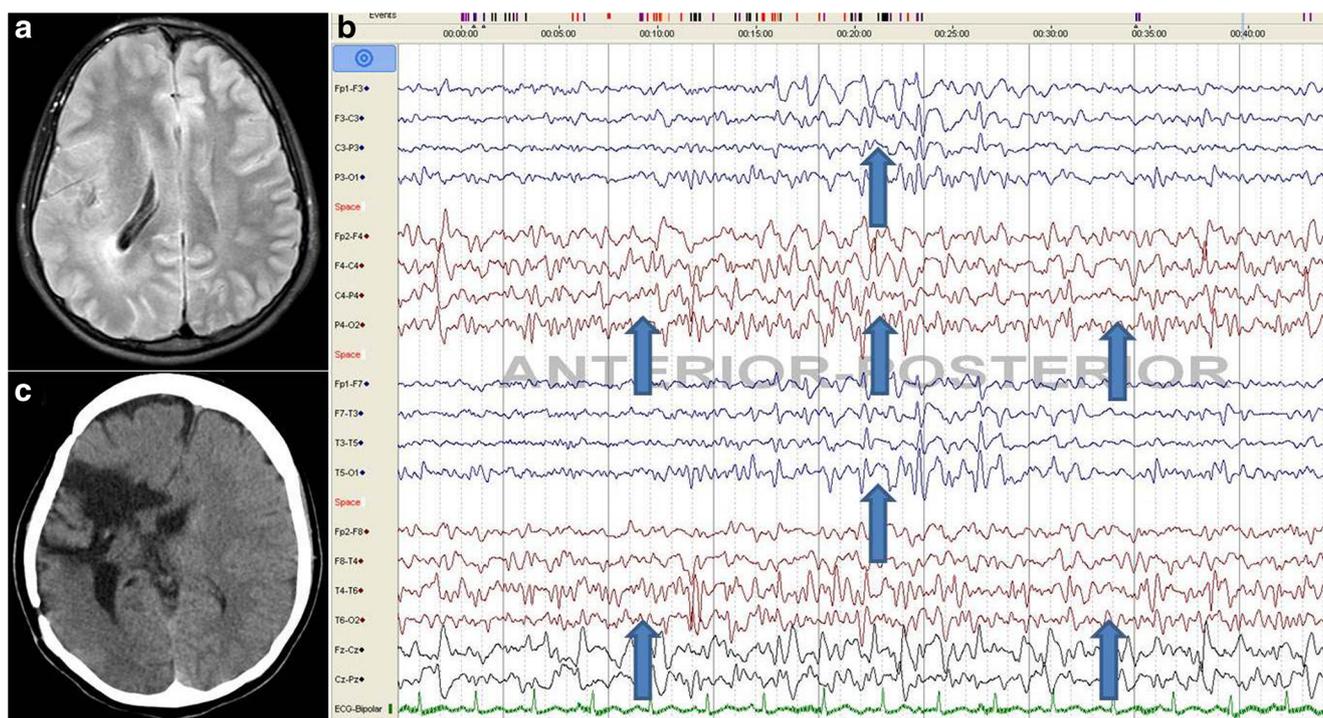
a MRI, b preoperative EEG, and c postoperative CT scan of a 10-year-old girl with refractory left focal motor seizures for 9 years. The right cerebral hemisphere is larger than the left, with polymicrogyria, suggestive of hemimegalencephaly. Her EEG showed multifocal interictal spike discharges (arrows) in both cerebral hemispheres, right more than left.
